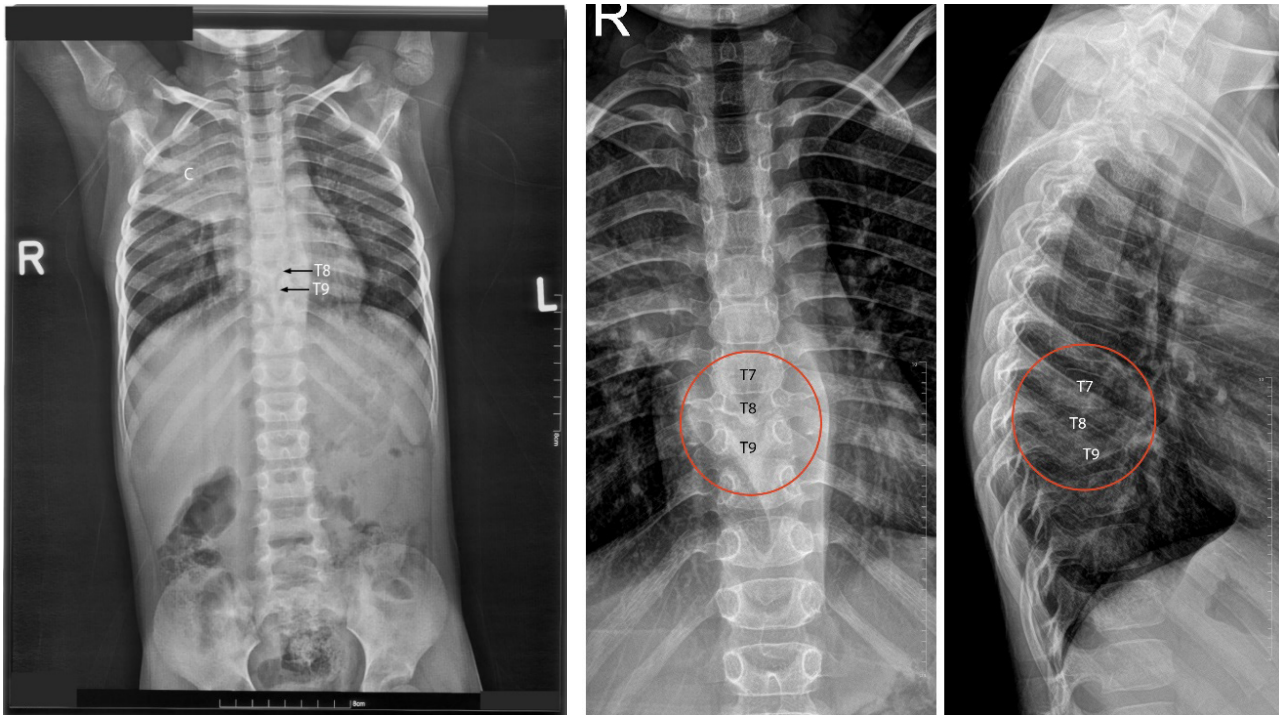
The first radiograph investigation of the patient shows right upper lobe consolidation (C) and loss of vertebral body at T8 and T9.
